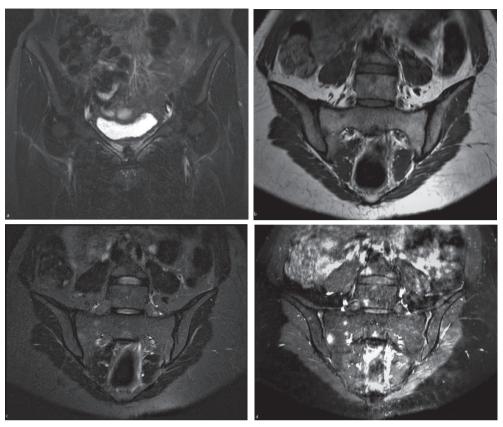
A: Coronal STIR MR image B: T1w coronal oblique MR image C: Coronal STIR MR image at the same level as above D: Contrast-enhanced T1w MR image with fat suppression enhancement.
